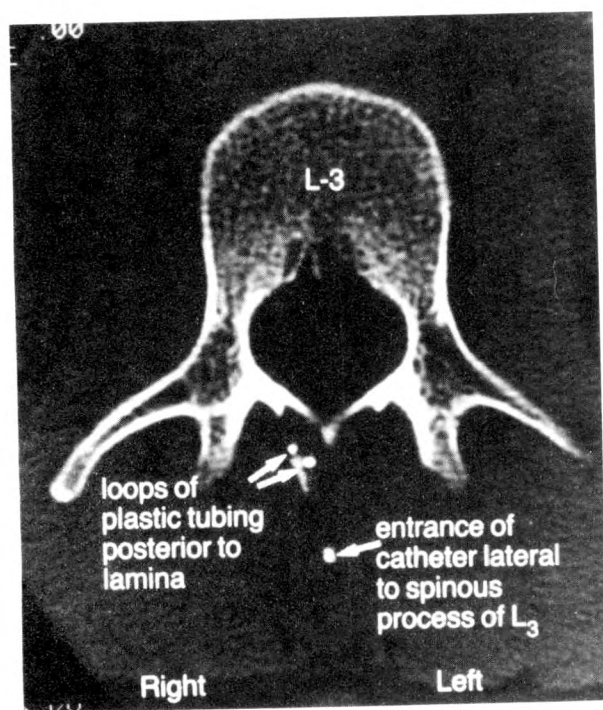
Localization by computed tomography of the plastic tubing lateral to the spinous process and posterior to the lamina of the vertebra.
